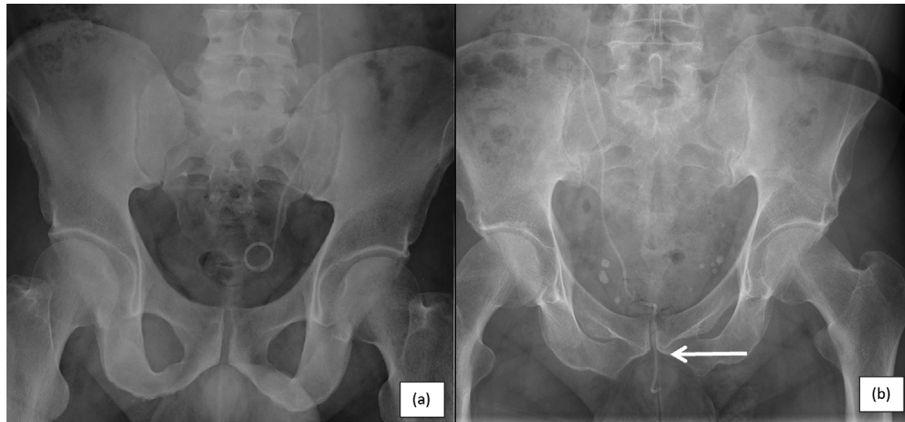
Plain radiographs demonstrating (a) the expected position of a left ureteric stent, in a different patient and (b) the film of the patient described in this case. The arrow demonstrates the distal portion of the right ureteric stent passing distal to the pubic symphysis, positioned in the penile urethra beyond the urinary sphincter.
